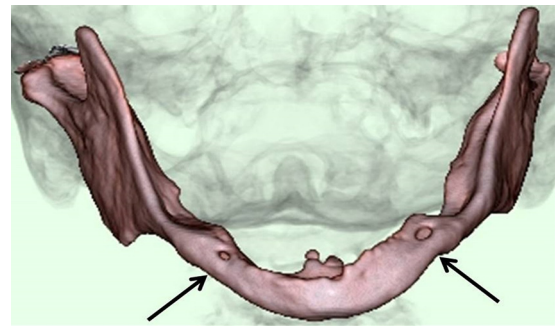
Preoperative 3D-CT findings in a patient with the chief complaint of severe pain in the mandible from wearing a complete denture. Mental region showed clockwise rotation (shown by black arrows).
